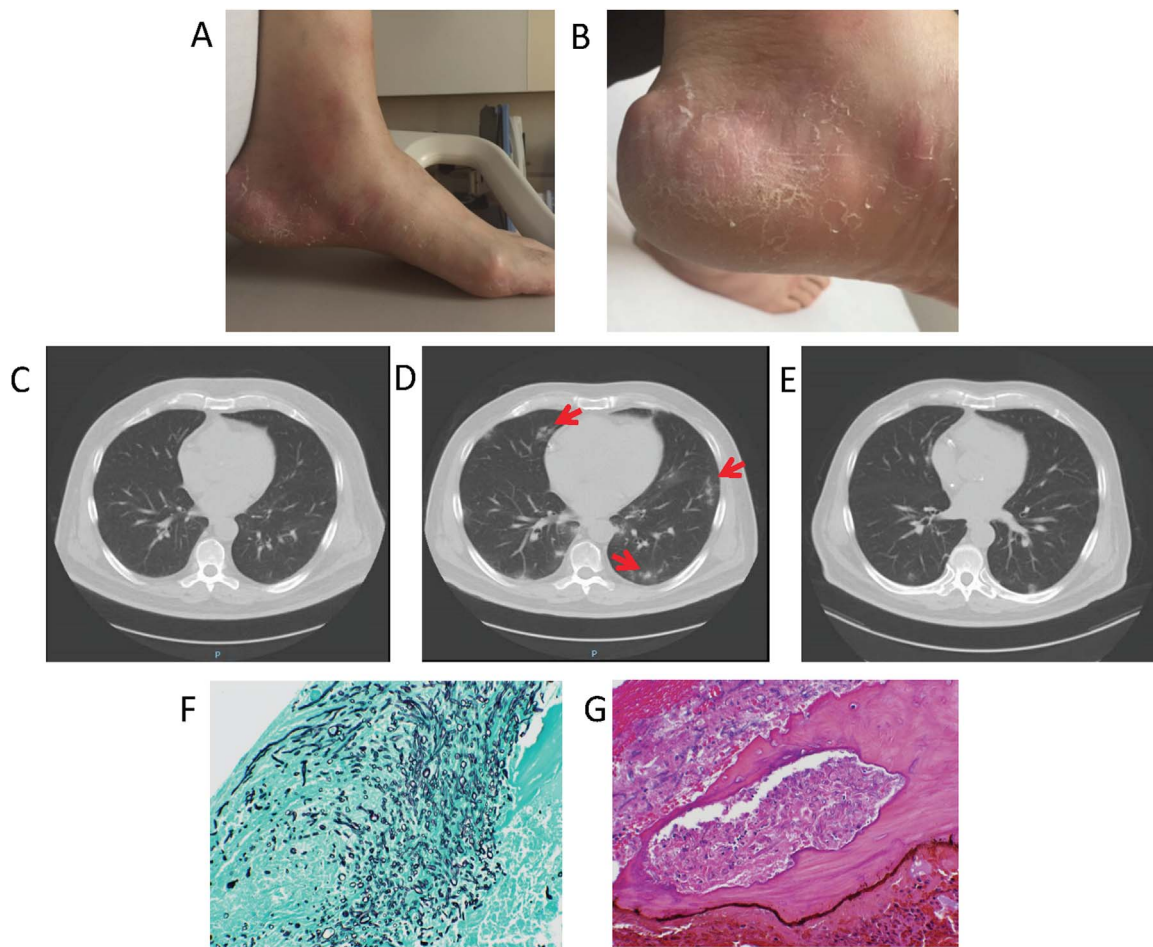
A- Left foot, ankle and lower legs showing erythema, swelling and nodules. B- Enlarged view of left medial heel nodule. C- Baseline CT chest. D- Week 3 CT chest with nodules and infiltrates (arrows). E- Week 15 CT chest with resolution of nodules and infiltrates. F- GMS 20×, showing *Fusarium* hyphae and spores identified in the left middle turbinate. G- H & E 20×, showing hyphae and spores in the bone of the nasal turbinate and surrounding soft tissues.
